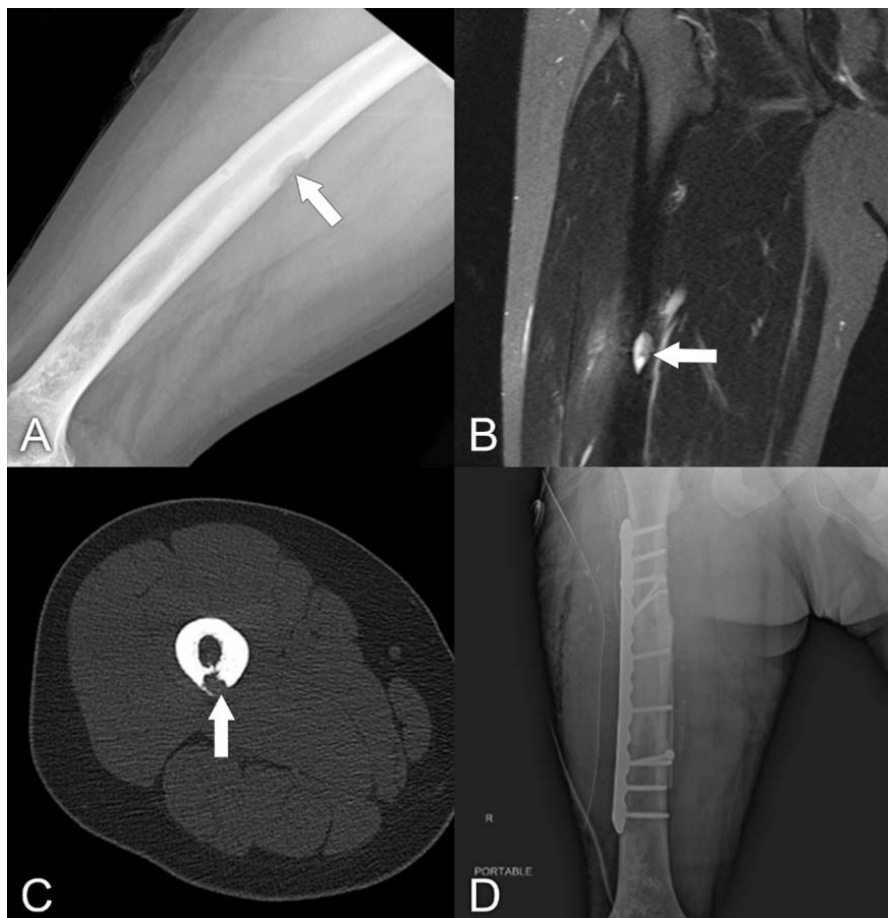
A 21-year-old male with metastatic retinoblastoma to the right femur who developed a radiation-associated osteosarcoma. (A) Plain radiograph shows a lytic lesion in the cortex of the right femoral diaphysis (arrow). (B) Coronal T1 post-contrast MRI shows an enhancing lesion in the cortex of the right femoral diaphysis (arrow). (C) Axial CT shows a lytic lesion in the cortex of the right femoral diaphysis (arrow). (D) Plain radiograph shows the right femur following tumor resection with repair using intercalated allograft and lateral stabilization with a long compression plate.
